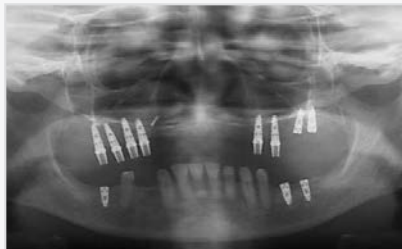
Panoramic x-ray image of 14, 15, 16, 17, 24, 25, 26 and 27 implants placement.
